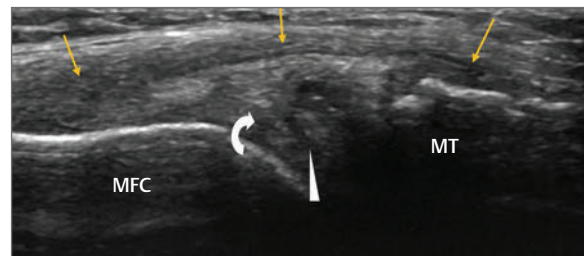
Longitudinal image of the medial aspect of the knee joint. The medial collateral ligament appears intact and can be seen over the joint line (yellow arrows). There is no evidence of significant degenerative change. The medial meniscus (curved white arrow) appears extruded with evidence of a C-shaped low echo foci within its substance (white arrowhead). These findings are in keeping with significant meniscal tear. MRI would be required to further evaluate the meniscus. MFC, medial femoral condyle; MT, medial tibial plateau; white arrowhead, meniscal tear.
